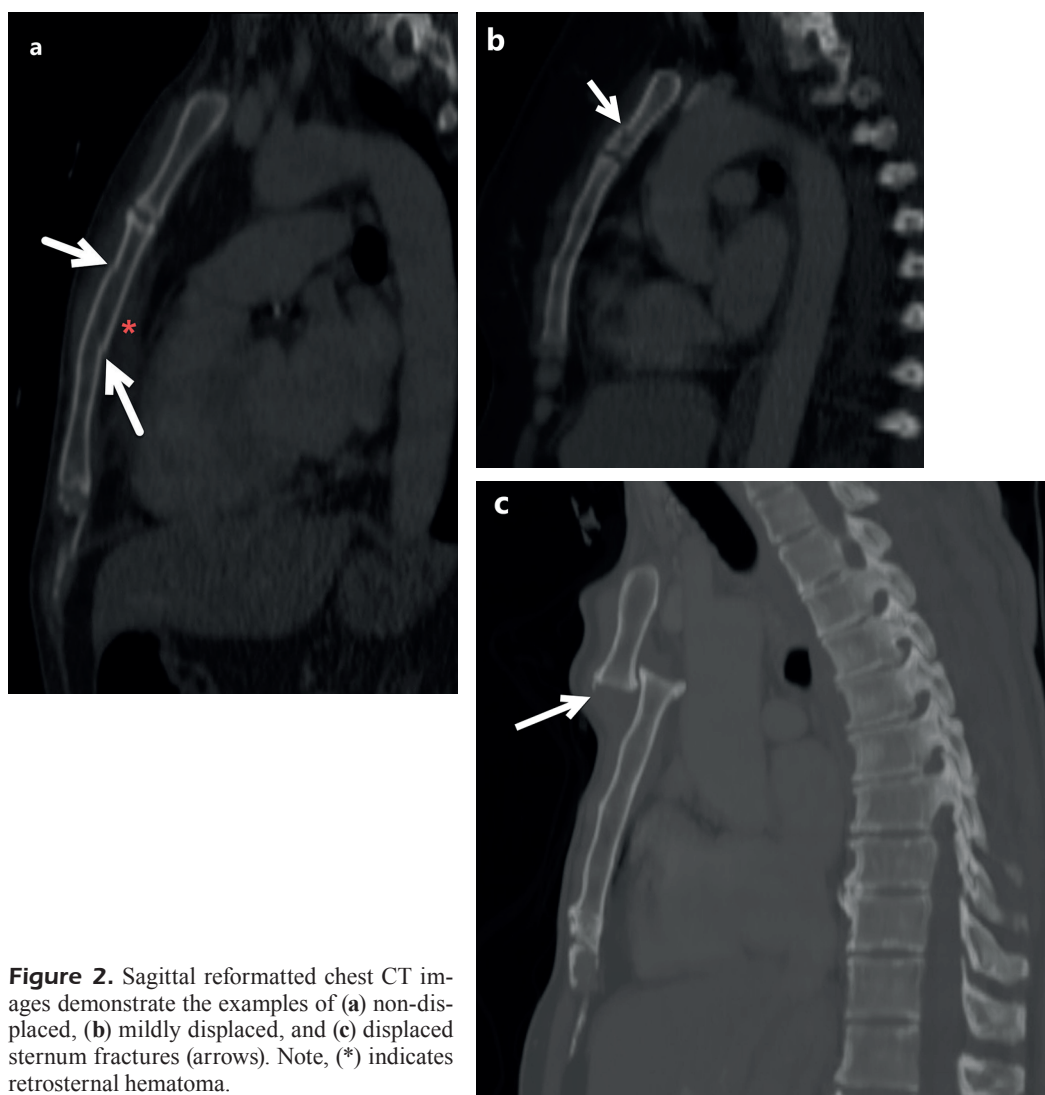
Sagittal reformatted chest CT images demonstrate the examples of (a) non-displaced, (b) mildly displaced, and (c) displaced sternum fractures (arrows). Note, (*) indicates retrosternal hematoma.
